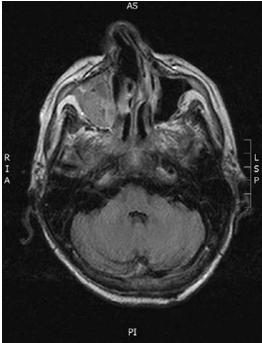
T1-weighted MRI
